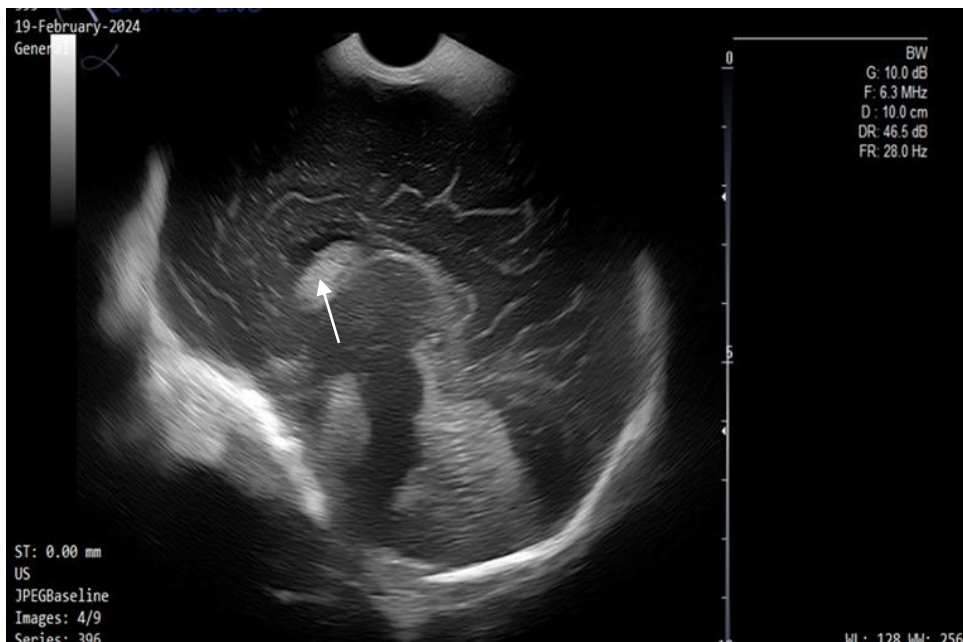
Sagittal plane Male neonate 40 weeks gestation, 2820 grams, CS delivery, NRFS Moderate HIE- Day seven cranial ultrasound post cooling showing grade II intraventricular hemorrhage.
